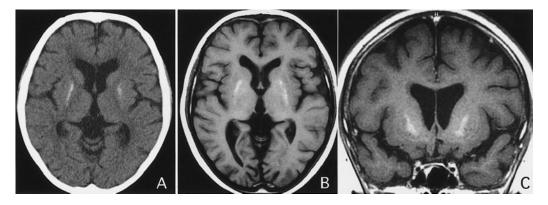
Case 3. (A) CT scan showing calcification of basal ganglia bilaterally. T1-weighted images of MR also showing paradoxical high signal intensity area in both basal ganglia (B) axial section; (C) coronal section
